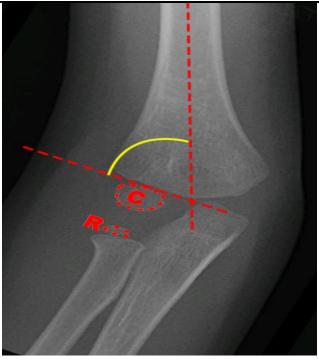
X-ray (AP view), Baumann's angle
